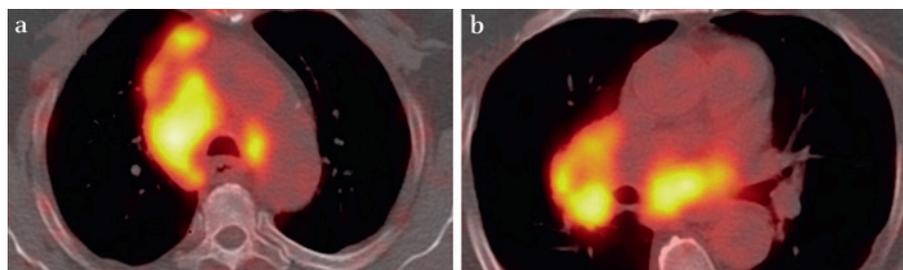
Positron emission tomography image demonstrating large intensely fluorodeoxyglucose (FDG)-avid masses in (a) pretracheal and (b) subcarinal and right hilar regions. *See page 138.*
